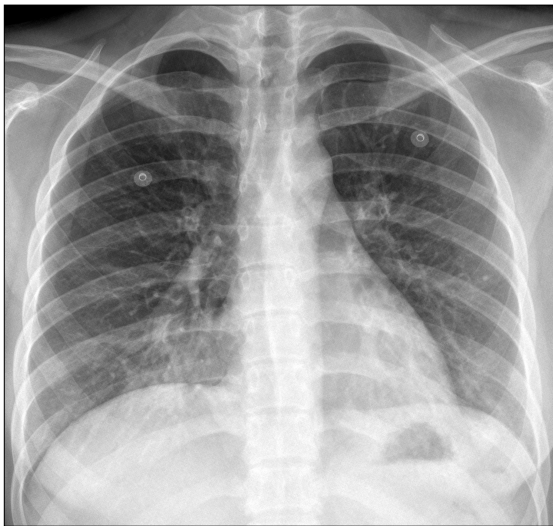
Initial chest radiography shows patchy increased opacities in both lower lung zones.
